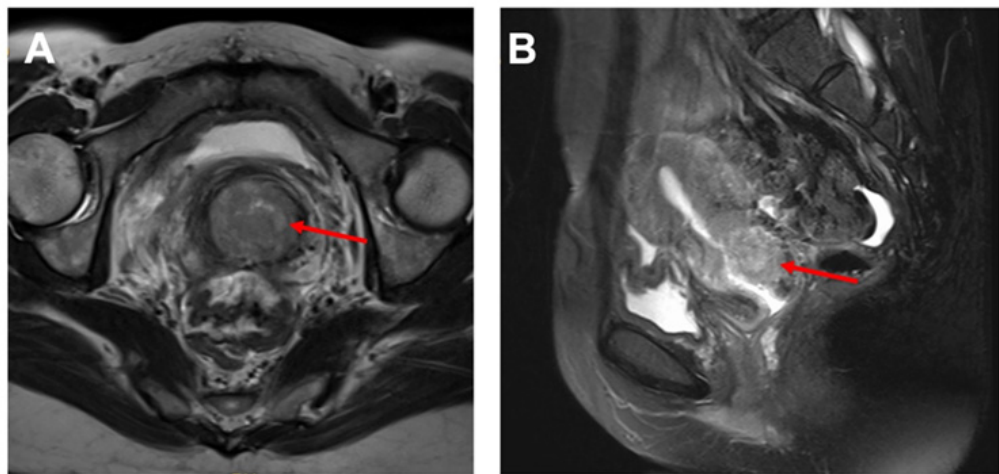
Preoperative pelvic magnetic resonance imaging (MRI) of the cervical mesonephric adenocarcinoma. (A) Axial and (B) sagittal views reveal a large (4.8 cm), heterogeneous, endophytic mass (indicated by red arrows) deeply infiltrating the cervical fibromuscular stroma. The tumour expands the cervix while maintaining a relatively intact external contour, a deceptive radiological feature that strongly mimics a benign cervical leiomyoma and significantly contributed to the initial diagnostic delay.
